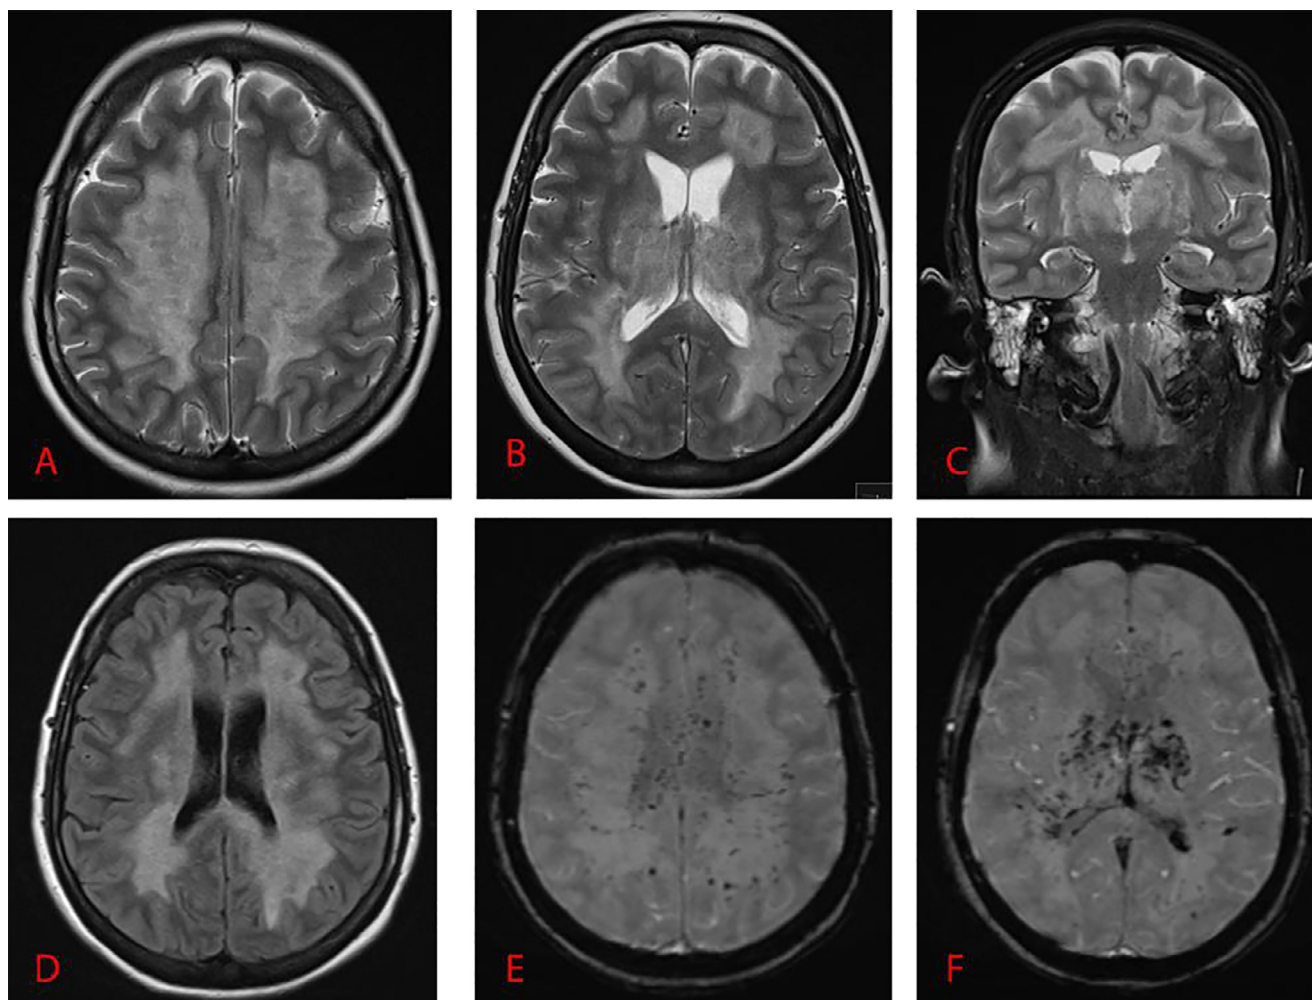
MRI of brain (second patient). Initial study. (A) and (B) Axial T2 WI, (C) coronal T2FS WI and (D) axial FLAIR WI: showing diffuse subcortical, deep white matter, periventricular, and basal ganglia increased signal intensity with multiple blooming artifacts indicating microhemorrhages in axial susceptibility weighted images (E) and (F).
